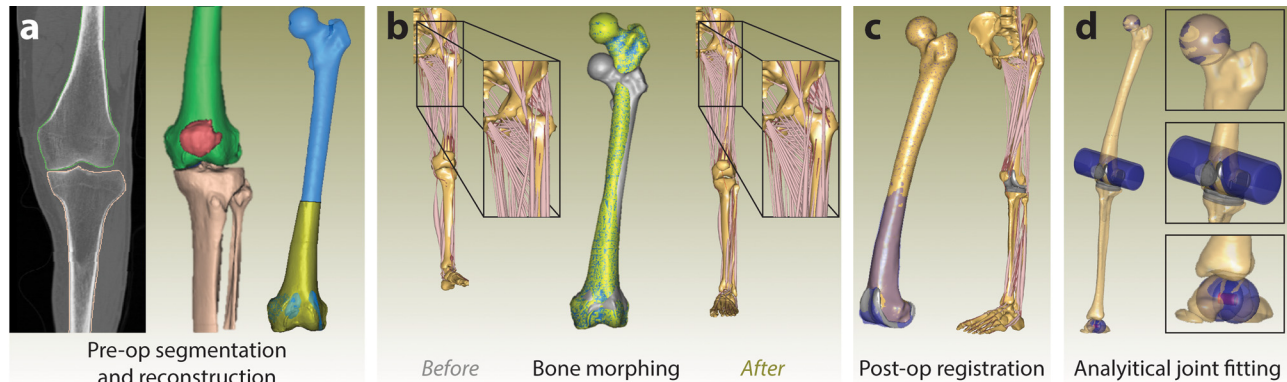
Steps for obtaining a subject-specific MS model. (a) Pre-operative bone segmentation from CT images. Partial bones were merged with postoperative bone geometries to generate complete 3D pre-operative bone models, (b) morphing of the generic TLEM 2.0 bone meshes to the patient-specific pre-operative bones (note the variation in muscle insertion sites), (c) registration of postoperative bone geometries to the morphed pre-operative bones, (d) analytical joint fitting of postoperative bone geometries to obtain patient-specific hip joint center, TF, PF, ankle, and subtalar joint axes.
